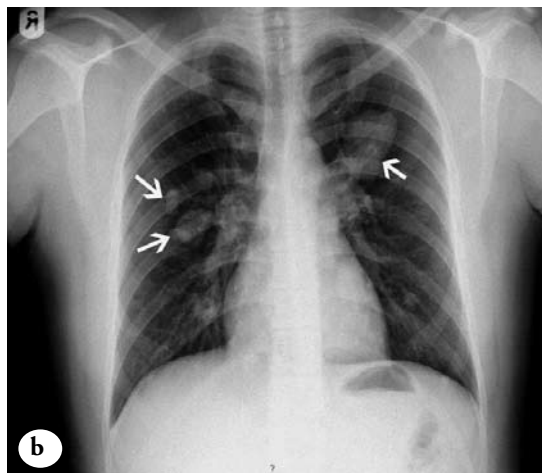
Radiological results of a) antero posterior and lateral views of the left ankle joint showing an ill-defined osteolytic lesion at the postero-medial aspect of the talus with bony outgrowth (arrow), and b) chest x-ray showing bilateral multiple lung metastases (arrows).
